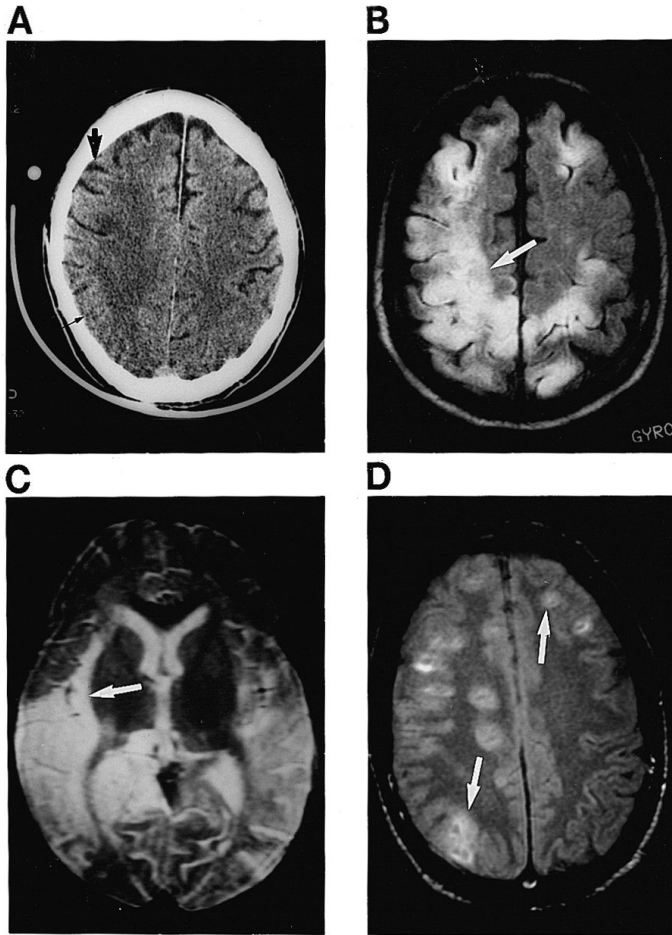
(A) Brain computed tomography (CT) changes that occur in most viral encephalitides. The scan demonstrates relative effacement of sulci posteriorly in both hemispheres (thin arrow), compared with normal sulcal spaces anteriorly (thick arrow). (B) MRI changes that occur in most viral encephalitides. T₂-weighted inversion recovery [fluid-attenuated inversion recovery (FLAIR)] MRI brain scan of the same patient demonstrates areas of heightened signal in both hemispheres, greater on the right and even more so posteriorly (arrow), reflecting increased water content in mildly swollen brain. (C) Herpes simplex virus encephalitis. T₂-weighted MRI brain scan demonstrates bilateral involvement of temporal lobes. The exaggerated signal does not extend beyond the insular cortex (arrow). (D) Varicella-zoster virus encephalitis. Proton-density brain MRI scan shows multiple areas of infarction in both hemispheres (arrows).
